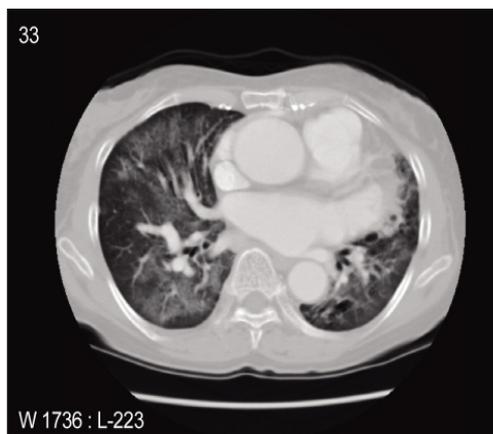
CT thorax done after chest drain insertion confirmed residual pneumothorax on right side and widespread lung consolidations.
